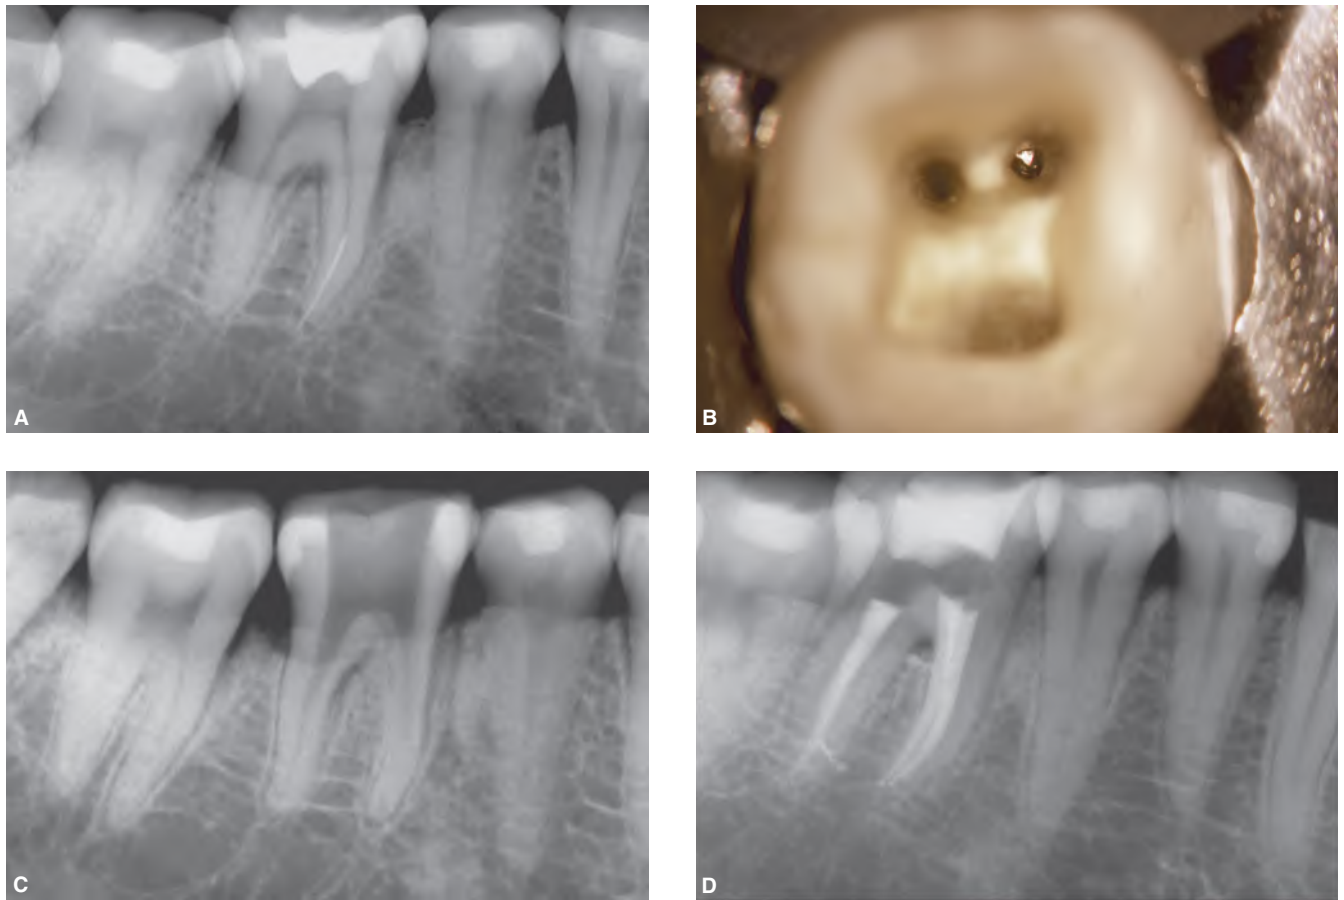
A. Preoperative radiograph of a mandibular left first molar with a separated instrument in the apical one-third of the mesial root. B. After refining access and completing ultrasonic procedures, a photograph reveals the head of the separated NiTi file predictably against the outer wall. C. A radiograph confirms straightline access and the removal of the separated file. D. Post-treatment radiograph shows the pack. Note, the furcal canal and that the distal system bifurcates apically.
